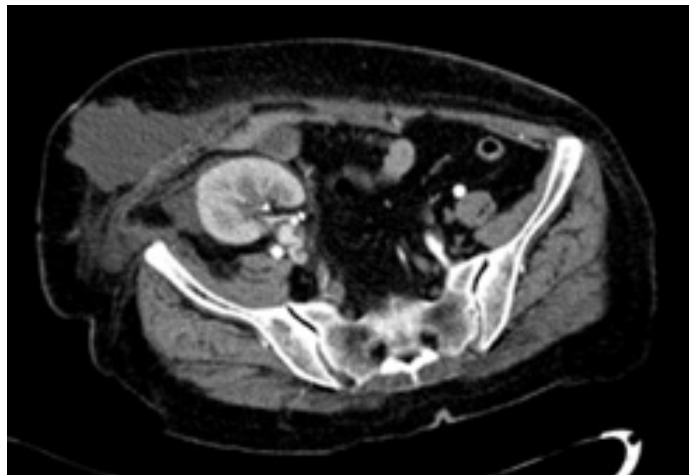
Image from computed tomographic angiogram.
